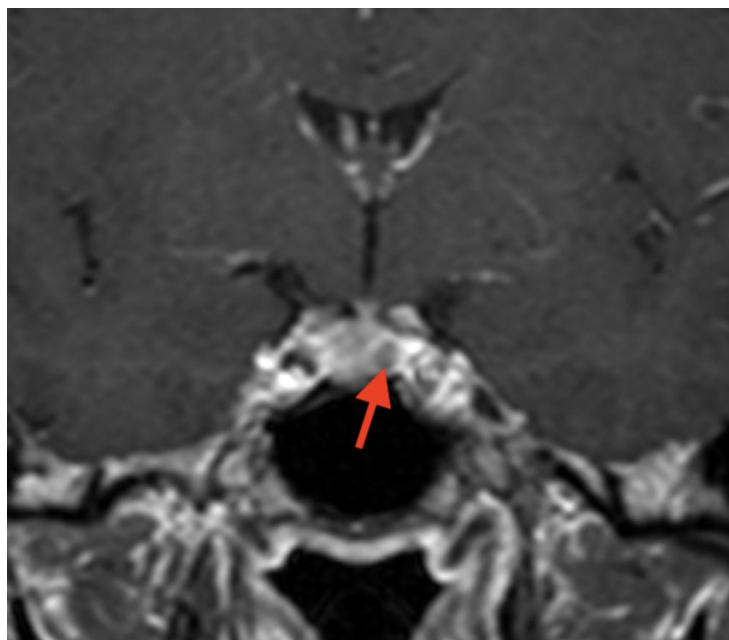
MRI 6 months after first surgery – pituitary adenoma on the left side (red arrow).
